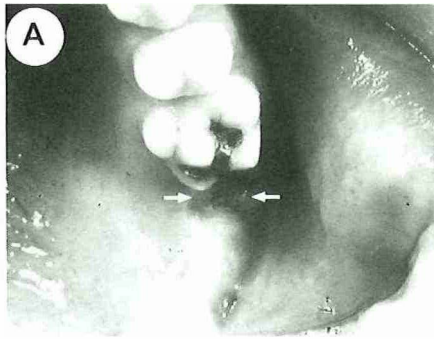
A Intraoral view of a 15-year-old girl with secondary retention of the maxillary left second molar (arrows). B Orthopantomogram of the same patient showing severe infraocclusion of the maxillary left second molar. The mandibular first and second molar on the right side are also affected. Note the amalgam restoration in the maxillary left second molar indicating that the molar had been emerged into the oral cavity.
